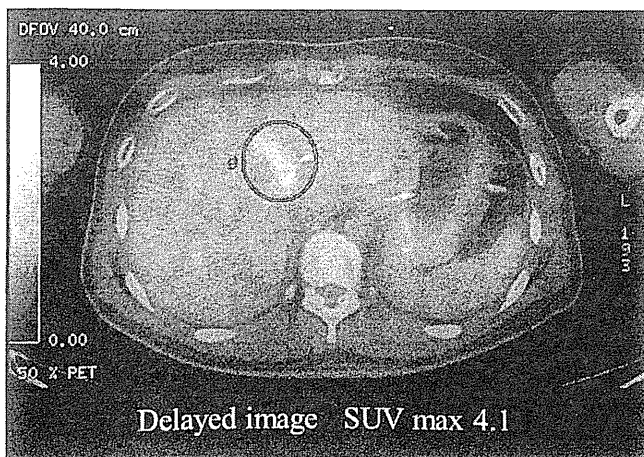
Positron emission tomography showed accumulation of F-18 fluorodeoxyglucose (FDG) in the left hepatic duct and dilated medial branch. Delayed image was obtained 2 hours after intravenous FDG injection.
